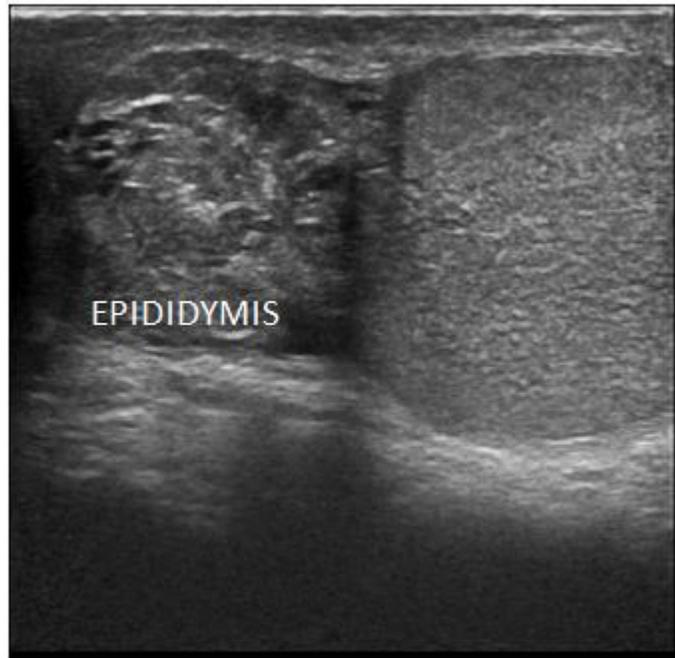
Sonography image showing Hyperechoic twisted left epididymis with the characteristic torsion knot or whirlpool pattern
